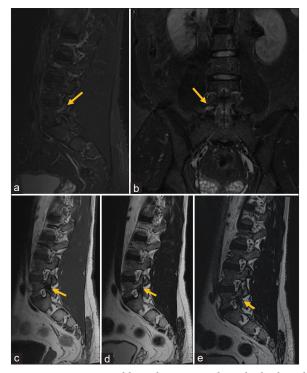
A 32-year-old male presented with back ache. (a and b) Sagittal and corresponding coronal fat-suppressed T2-weighted images of lumber spine show edema (arrow) in the right pars interarticularis at L5-S1 level suggesting stress edema. (c-e) Sagittal T1W, T2W, and SPC sequences acquired after 2 weeks show thin hypointense fracture line (arrow) at the same location.
